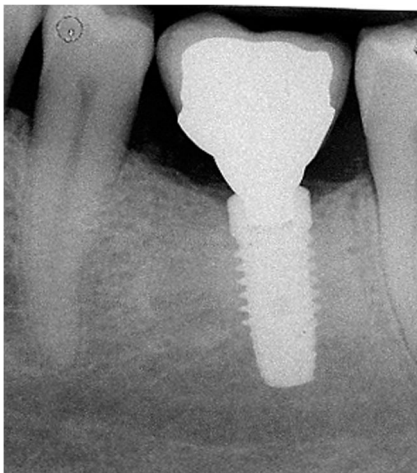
Radiograph taken after 3 years of function shows very low marginal bone loss as compared to prosthesis delivery stage
